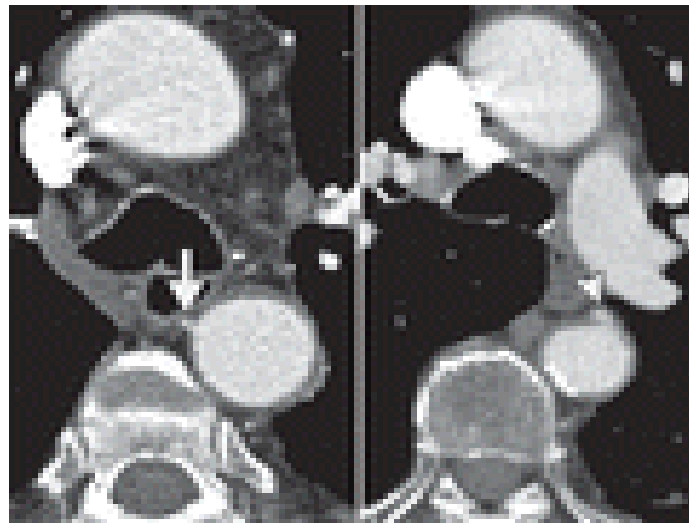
Normal orthotopic and ectopic bronchial arteries. (a) Axial computed tomographic (CT) angiograms show an orthotopic right bronchial artery (arrow) originating from the anteromedial thoracic aortic wall and an orthotopic left bronchial artery (arrowhead) originating from the anterior thoracic aortic wall. The normal bronchial arteries (arrows) as small nodular or linear enhancing mediastinal structures with a small diameter (<2 mm) (*Walker et al., 2015*).
